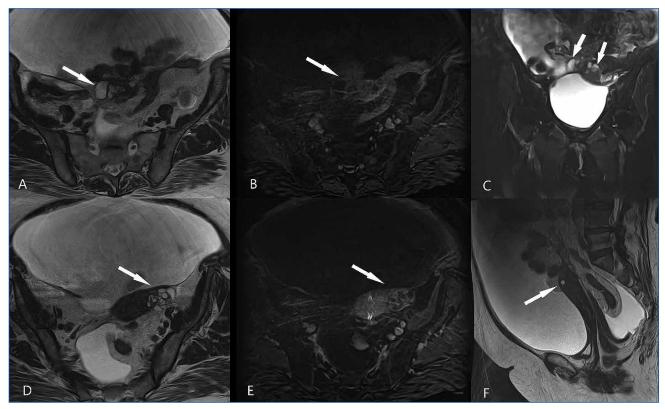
MRI of pelvis. A) Axial section T2 – tumoral transformation of the right ovary. B) Axial section T1 3D fatsat – lower signal intensity in cystic component of the ovary. C) Coronal section T2 fatsat – the high signal intensity suggests the cystic transformation of both ovaries. D) Axial section T2 – cystic transformation of the left ovary. E) Axial section T1 3D fatsat – high signal intensity in the solid component of the ovary; no clear demarcation limit between left ovary and the uterus. F) Sagital section T2 – uterus leiomyoma. All the sections reveal a large amount of ascites fluid
